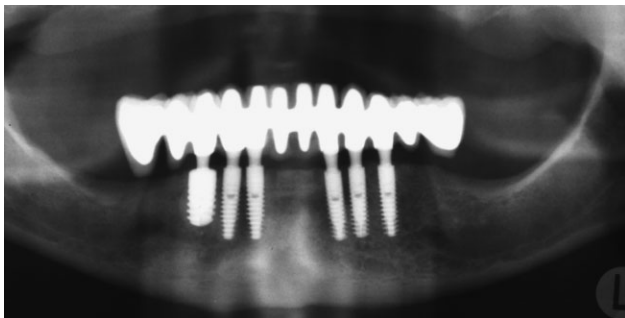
Seven years postoperative radiograph demonstrating crestal bone stability around implants with platform switching.
